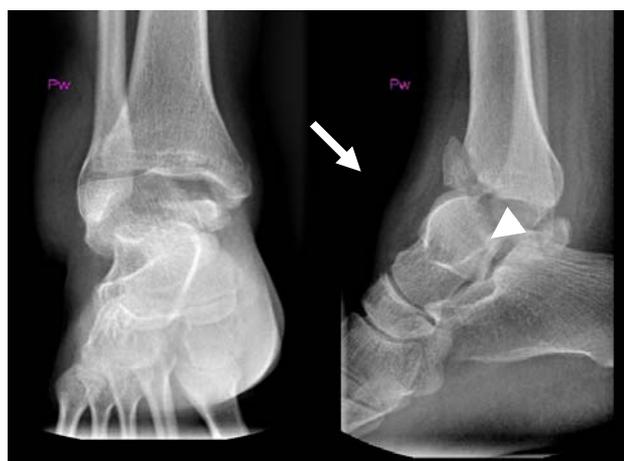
Sixteen years old female patient. Plain radiography (anteroposterior and lateral views) - on the lateral view two intermediate fragments probably separated from tibia (arrow) and talus (arrowhead).
